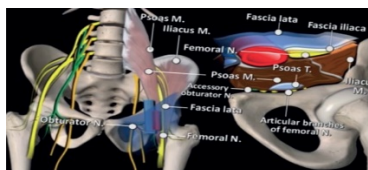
Vascular, nervous, muscular landmarks for ultrasound navigation
